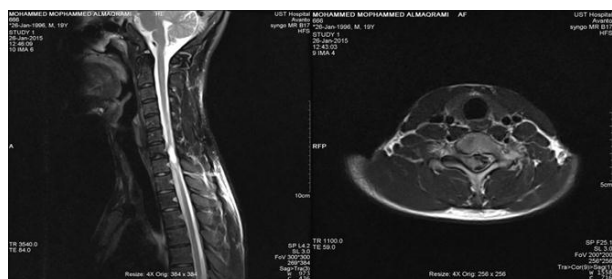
MRI scans of the affected cervical area
